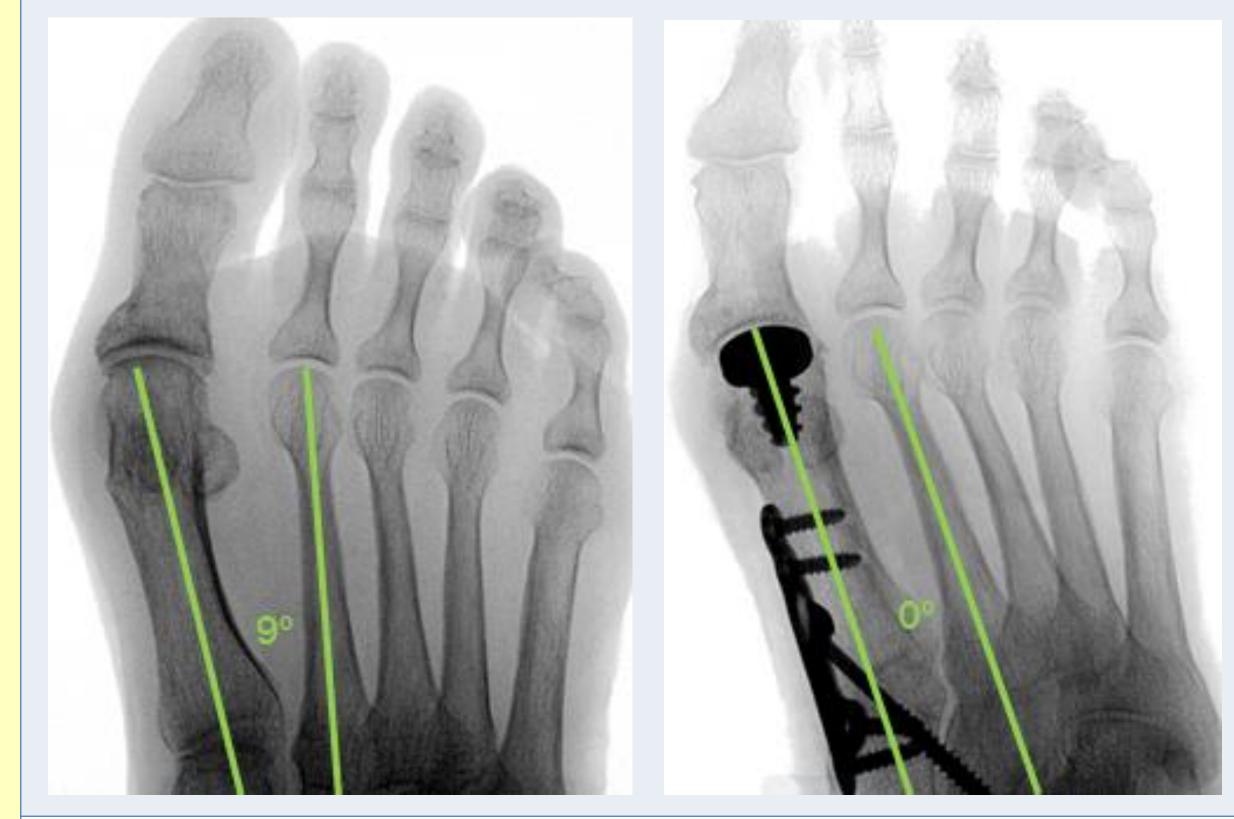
Final Intraoperative Radiographs
